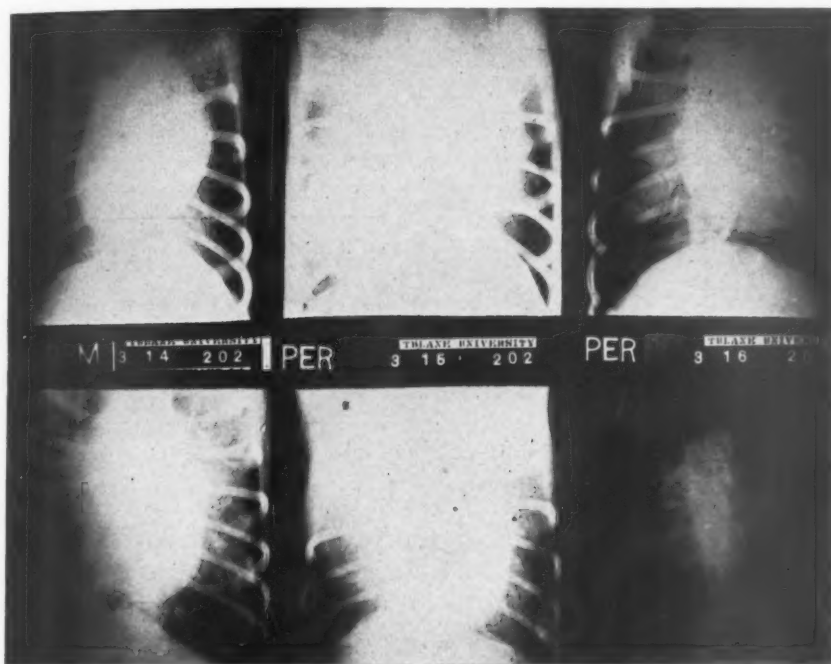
A short series of roentgenograms showing how the enlarged shadow of the acute pericardial effusion decreases and the gradual slight cardiac enlargement supersedes.
